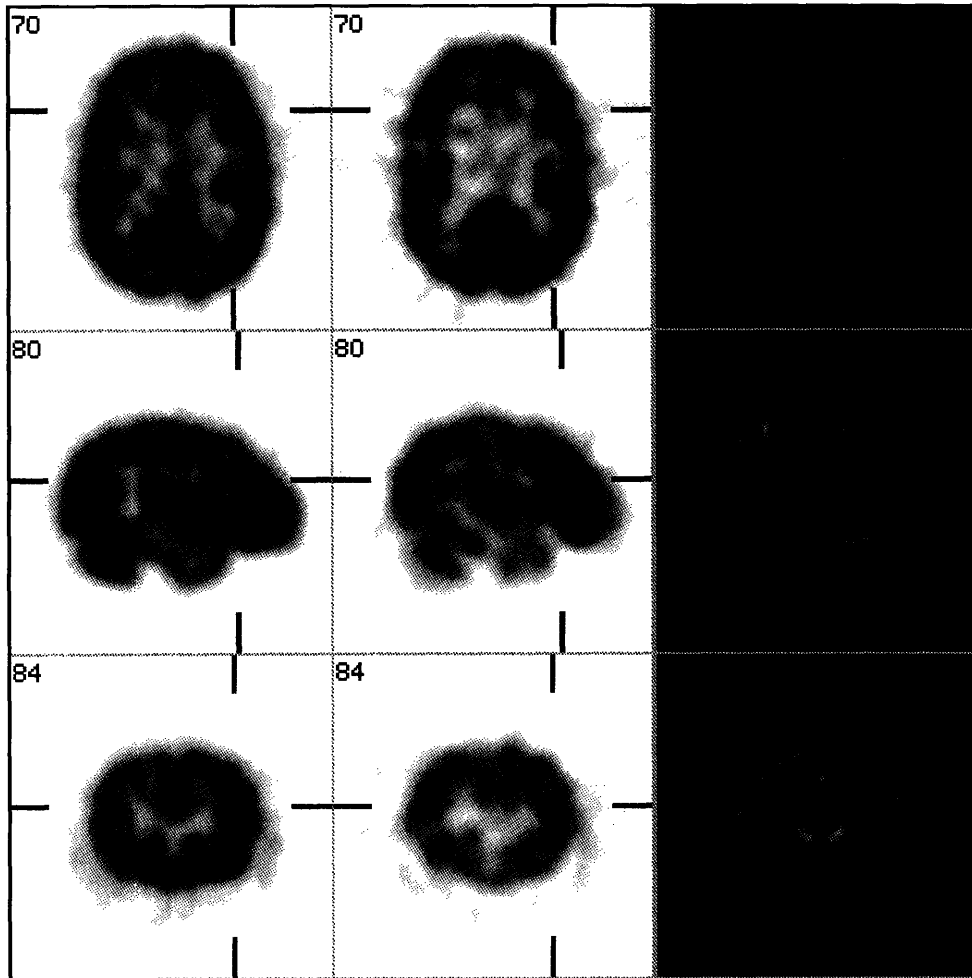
Complex partial seizures with normal inter-ictal SPECT (left) and MRI (right) and abnormal ictal SPECT (center). Yellow corresponds to low perfusion while black to high perfusion.
